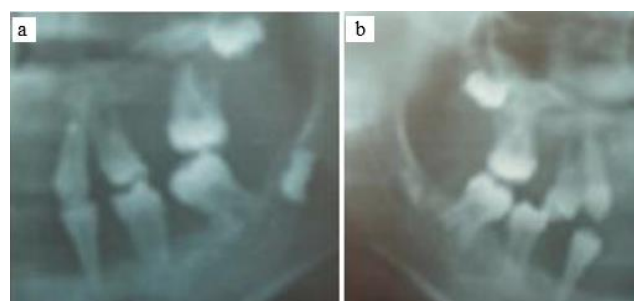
a,b: Radiograph shows prominent alveolar bone loss surrounding the teeth, which leads to spaced-out appearance
